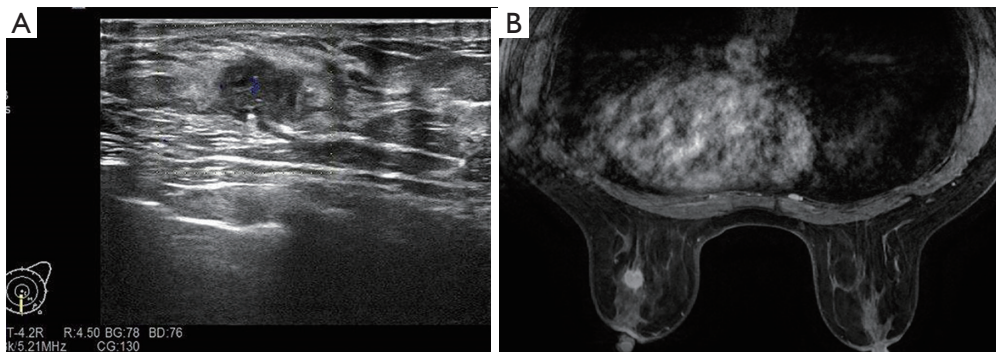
Patient's examination results. (A) Breast ultrasound results. (B) The patient's breast magnetic resonance images.
